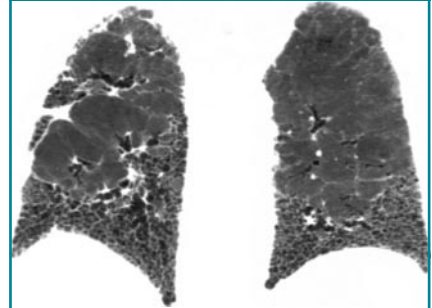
Coronal CT scan shows reticular opacities and honeycombing in the lower zones, typical of idiopathic pulmonary fibrosis.
